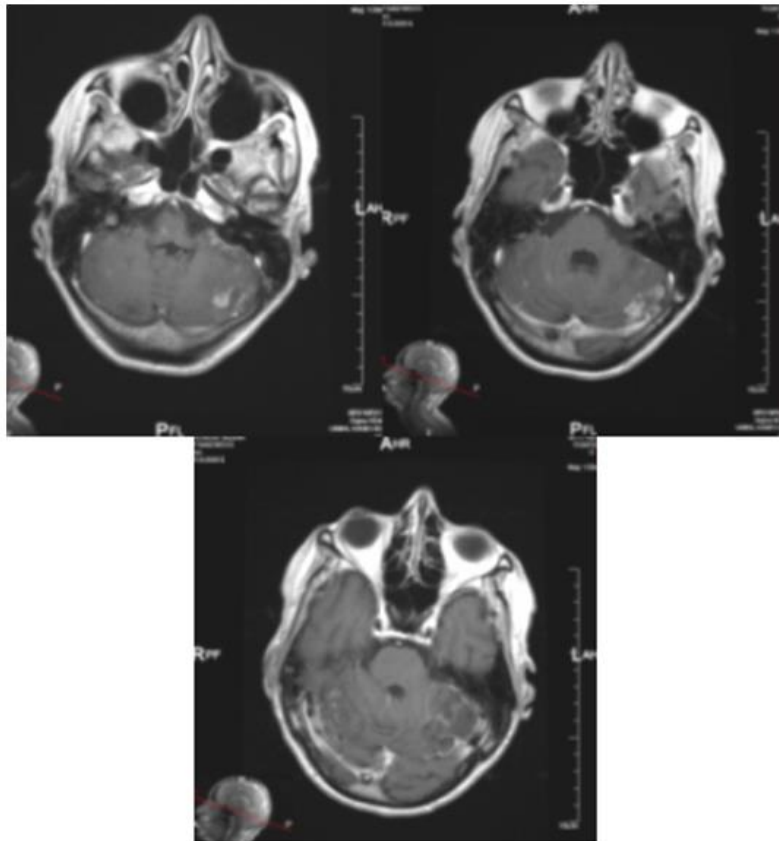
AX T1 FLAIR+C MR postcontrast images after 4 months of RT and after 3 months of targeted therapy alone
